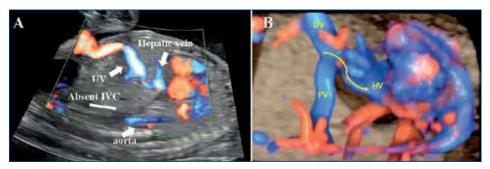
Vascular abnormalities detected in the upper abdomen. A: Color Doppler imaging, showing agenesis of *ductus venosus* with umbilical vein (UV) drainage into a hepatic vein (HV). B: 4D STIC volume presenting interrupted inferior *vena cava* (IVC) and hepatic drainage of the UV (UV: umbilical vein; PV: portal vein; IVC: inferior *vena cava*)
